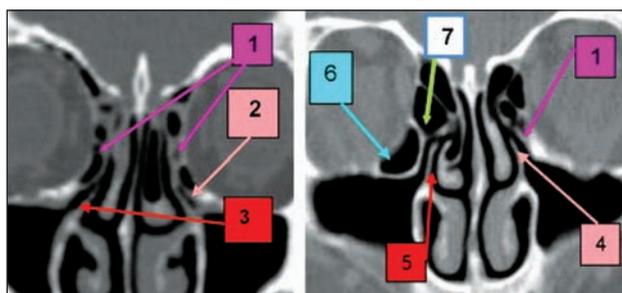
Paranasal sinuses CT scan, bone reconstruction, coronal slices: 1. left lamina papyracea; 2. left uncinate process inserted into the lamina papyracea, adherent to the external nasal wall with maxillary sinus ostium obstruction; 3. right uncinate process inserted into the lamina papyracea; 4. left uncinate process inserted into the lamina papyracea; 5. right uncinate process inserted into the ethmoid bulla; 6. Haller cell; 7. ethmoid bulla
